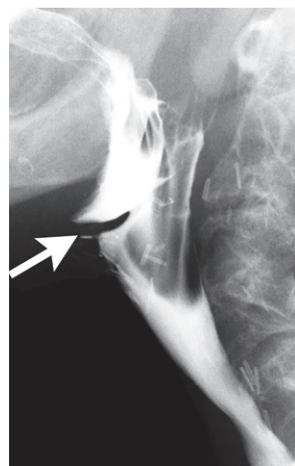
Pseudoepiglottitis in a 78-year-old man who underwent a total laryngectomy. Lateral radiograph during swallowing shows a linear horizontal filling defect in the anterior wall of the proximal neopharynx that resembles the epiglottis and partially obstructs the passage of the bolus (arrow).
